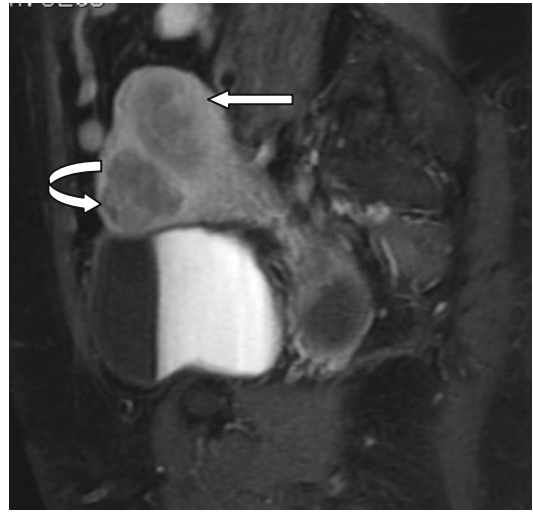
63-year-old lady with postmenopausal bleed, T1 sagittal and axial MRI showing mass in the endometrial cavity infiltrating the myometrium, more than 50 % thickness (*straight arrow*). An anterior wall fibroid (*curved arrow*) is also noted
